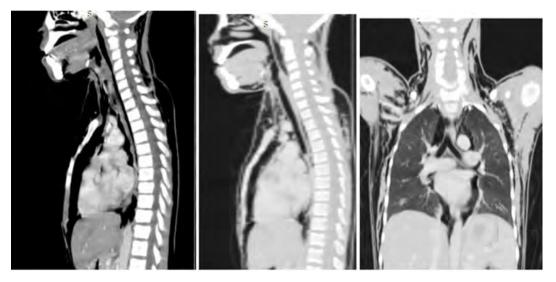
Coronal sections of abdomen, chest and neck CT-scan with contrast shows pneumomediastinum and subcutaneous emphysema and normal gross radio-anatomic image of major mediastinal airodigestive structures (esophagus and trachea)
